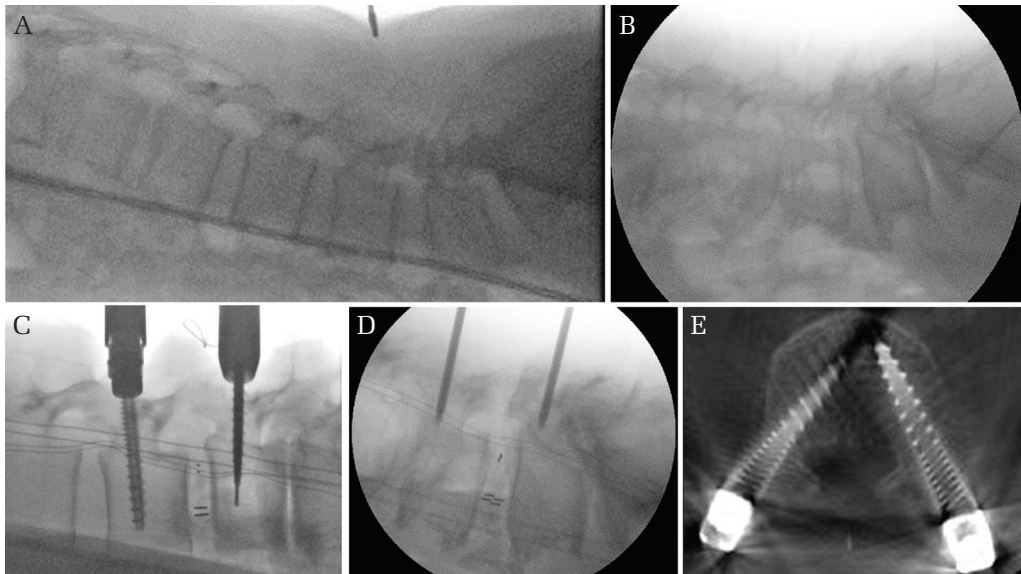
Intraoperative imaging. (A, B) Fluoroscopic image with a multi-axis angiography unit (A) and C-arm (B). These figures show that a larger field of view and higher image quality are obtained in a multi-axis angiography unit. Seven or more lumbar and sacral vertebrae can be viewed on the monitor of a multi-axis angiography unit in a hybrid OR. (C, D) Percutaneous pedicle screw (PPS) with a multi-axis unit in a hybrid OR (C) and C-arm (D). The tips of the guide wire can be seen clearly with a multi-axis angiography unit. (E) The resolution of a CT-like image using a hybrid OR is sufficient to judge the deviation of screws. Intraoperative CT-like image is not available with the C-arm.
